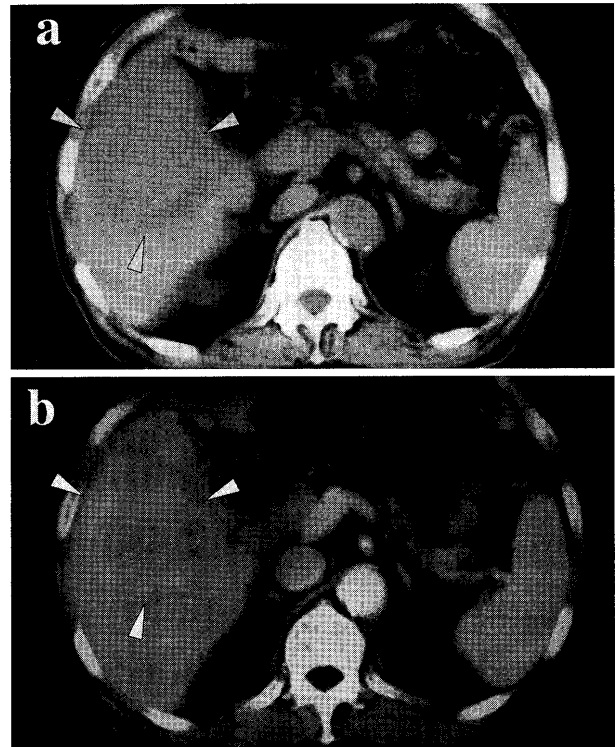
Plain CT scans performed on 4 days after admission revealed irregular and heterogeneous low-density area in the anterior segment of the liver (a), and which was weakly enhanced by the contrast CT (b).
